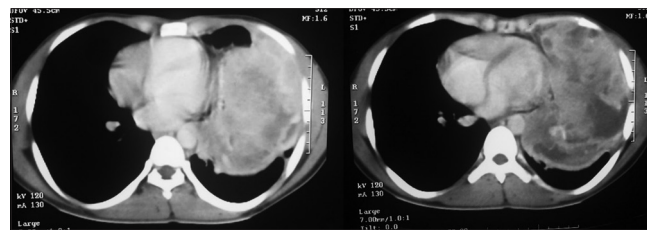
Contrast enhanced computed tomography chest showing mass lesion with contrast enhancement with areas of necrosis
